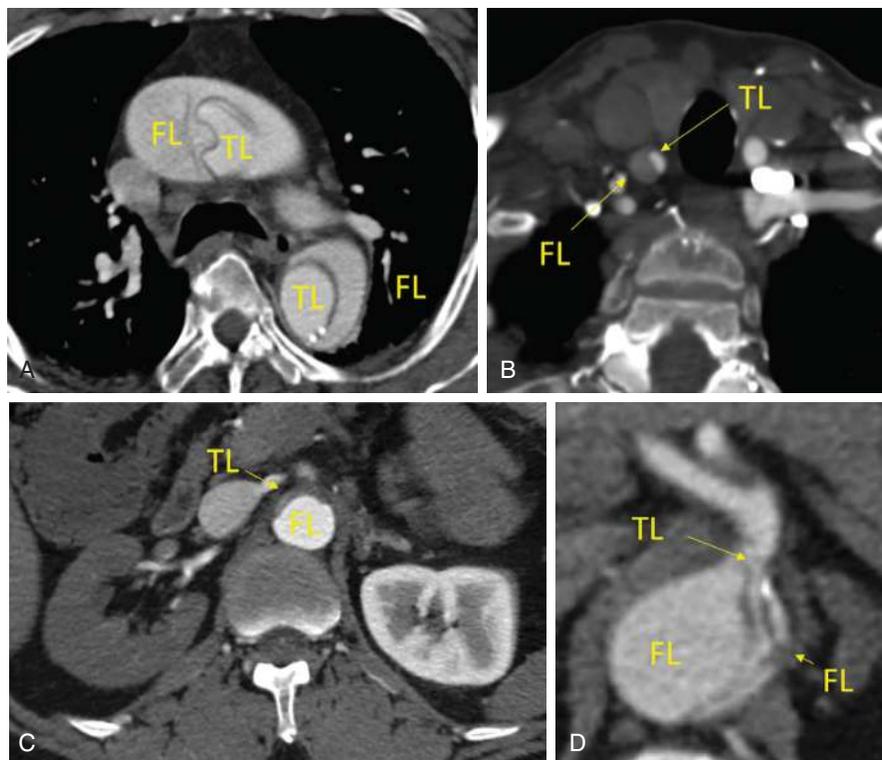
Computed tomography in a patient with malperfusion syndrome (axial view). (A) Axial image of a type A aortic dissection at the level just below the tracheal bifurcation. (B) The right common carotid artery is dissected and the true lumen is compressed by the false lumen. This patient presented with altered mental status. (C) The right renal artery branches off from the compressed true lumen with resultant malperfusion (no enhancement with the contrast). (D) The celiac artery branches off from the narrowed true lumen. However, the patient did not present with malperfusion syndrome (normal liver functions, no abdominal pain). *FL*, False lumen; *TL*, true lumen
